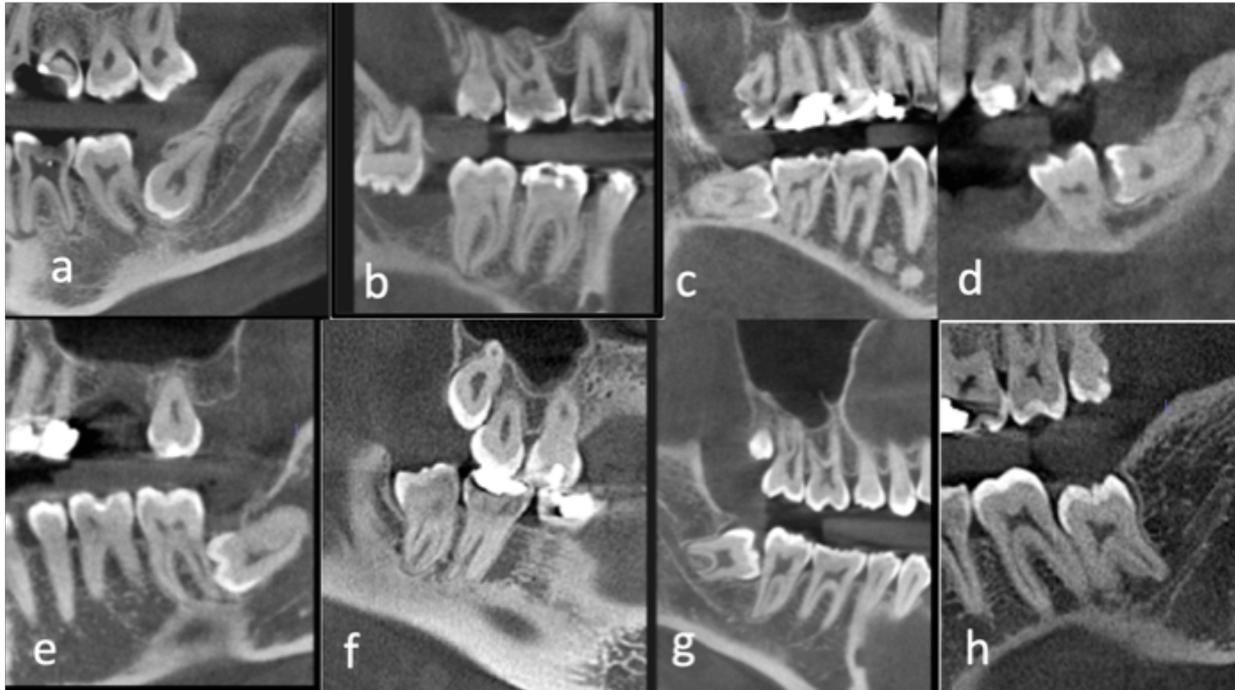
Eight cropped and reformatted panoramic CBCT sections of impacted mandibular molars, showing Winter's angulations and positions. (a) and (b) Inverted angulation. (c) Horizontal angulation with hypercementosis. (d) Position B; horizontal angulation. (e) Position C; horizontal angulation. (f) Position A; distoangular. (g) Position B; mesioangular. (h) Position B; vertical angulation.
